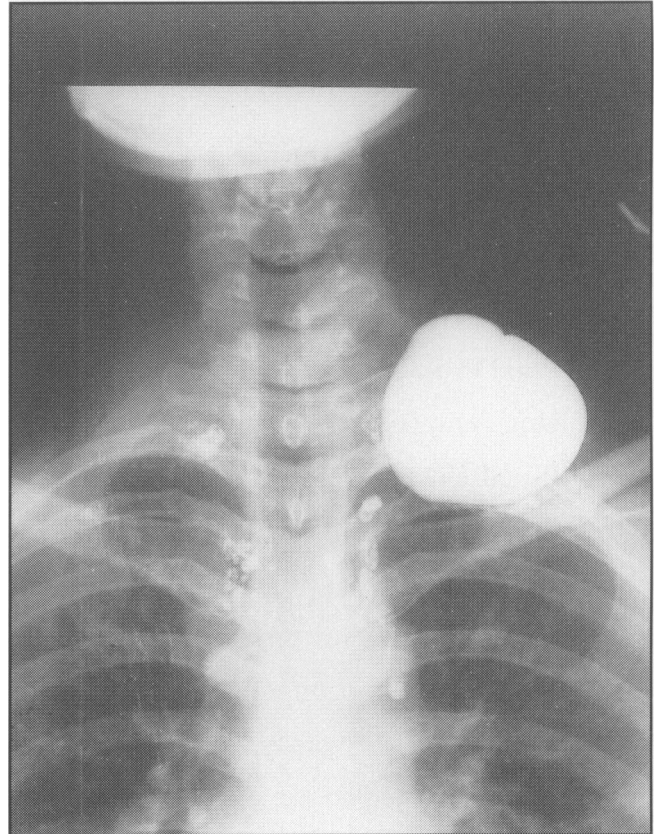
Radiography of the cyst.
